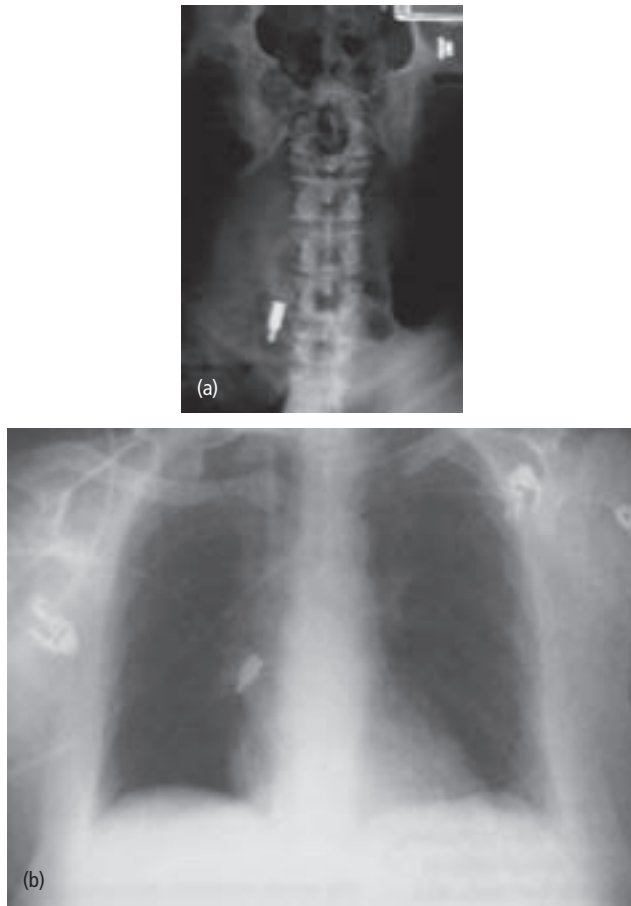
(a, b) Radiographs showing a screwdriver that was swallowed.
